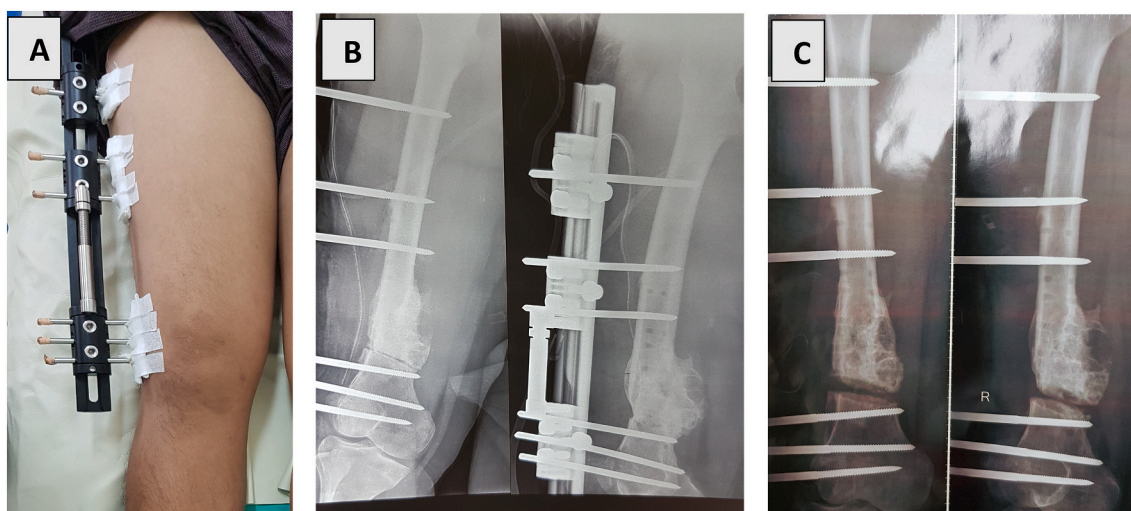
A. Monorail Fixator, B. Immediate Post-operative radiograph after monorail application, C. After 2 weeks of bone lengthening.
